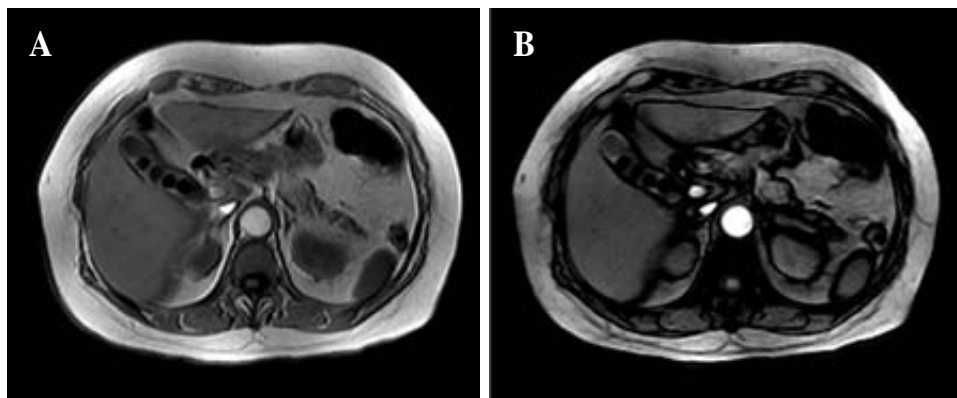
Magnetic resonance imaging of the liver, axial plane. A–B, In- and out-of-phase gradient echo images, respectively. There is a subtle signal drop resulting from the phase cancellation of fat and water in this patient with grade I steatosis.
